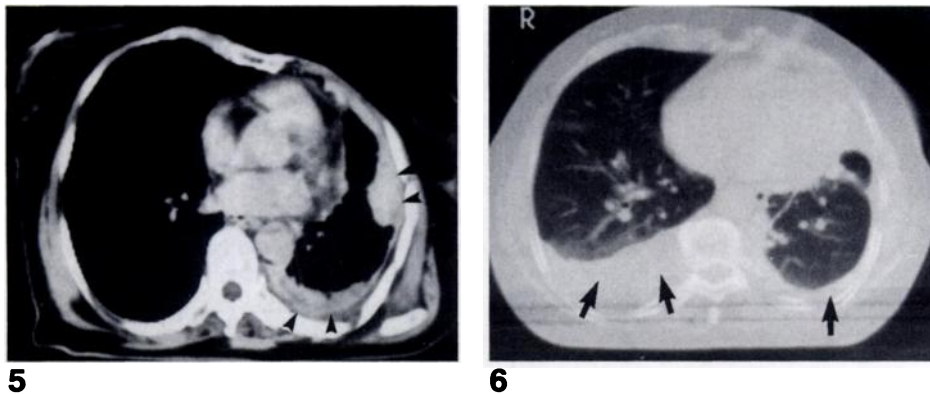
57-year-old woman with malignant pleural mesothelioma who had been exposed to erionite. CT scan shows volume loss of left hemithorax along with rib crowding. Pleural thickening and masses (arrowheads) involve all pleural surfaces. Mediastinum is pulled to left side. Pleural biopsy revealed malignant mesothelioma.
